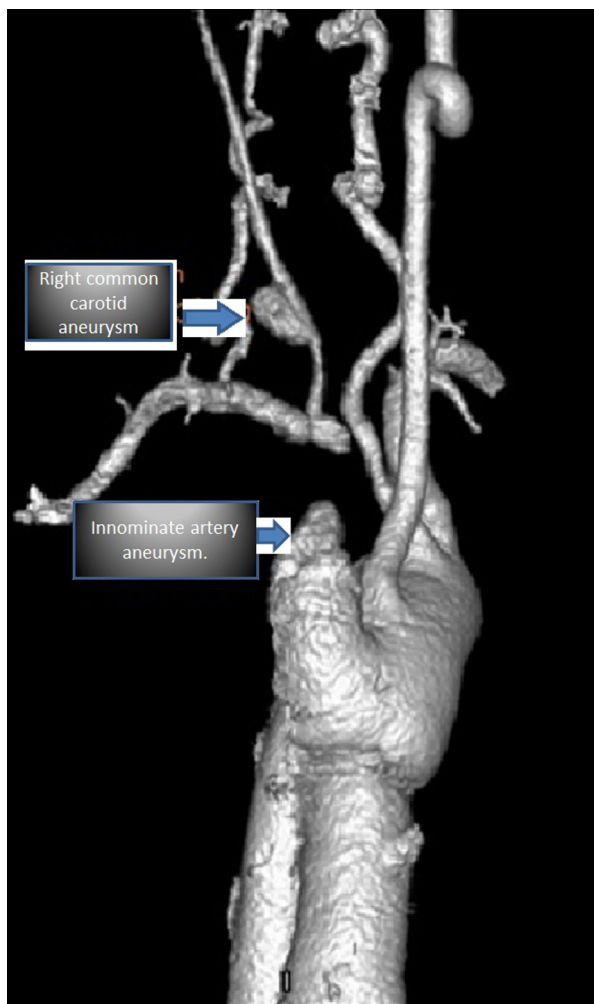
Computed tomography angiogram of the neck, chest and abdomen showing right common carotid artery and innominate artery aneurysm.
